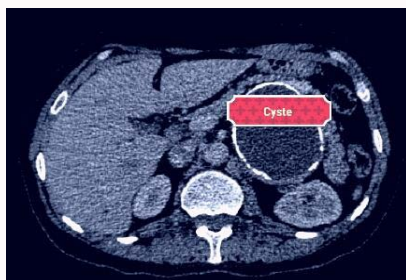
CT shows the adrenal cyste.
